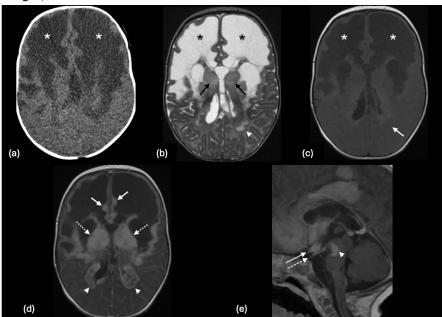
(a) Axial non-contrast CT shows diffuse bifrontal white matter hypodensity, (asterisks), extending into the bilateral basal ganglia. (b) Axial T2WI MR shows diffuse cystic hyperintensity within the bifrontal white matter extending from the ventricular margins to the subcortical U-fibers (asterisks); a hypointense periventricular rim, (arrowhead); and mild hyperintensity and swelling of bilateral striata, (arrows). (c) Axial T1WI MR shows diffuse bifrontal white matter hypointensity (asterisks), with a hyperintense periventricular rim, (arrow). (d) Axial post-contrast T1WI MR shows thick enhancement along the margins of the cystic changes in the frontal lobes, (solid arrows), along the periventricular rim, (arrowheads), and within the striata, (dashed arrows). (e) Sagittal post-contrast T1WI shows leptomeningeal enhancement involving the optic chiasm, (solid arrow), oculomotor nerves, (dashed arrow), and within the interpeduncular cistern, (arrowhead).
